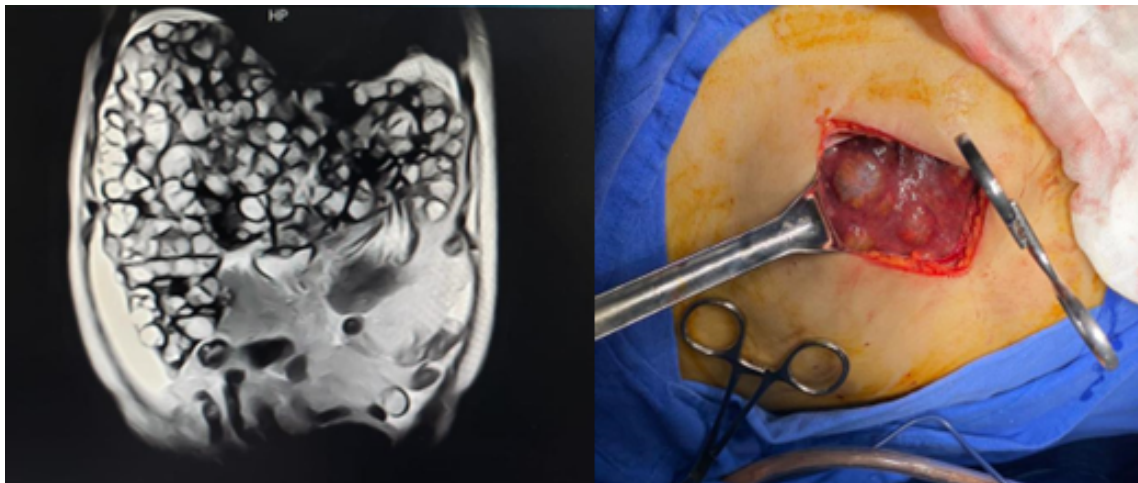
A. Magnetic resonance imaging with heterogeneous echogenicity due to multiple images of diffuse distribution, predominantly cystic, with fluid levels, ranging from 20 to 40 mm, in the entire liver parenchyma, compatible with Gigot type 3 polycystic liver disease. B. Macroscopically observed ovoid fibrous-like lesions occupying more than 80 % of the liver parenchyma.
